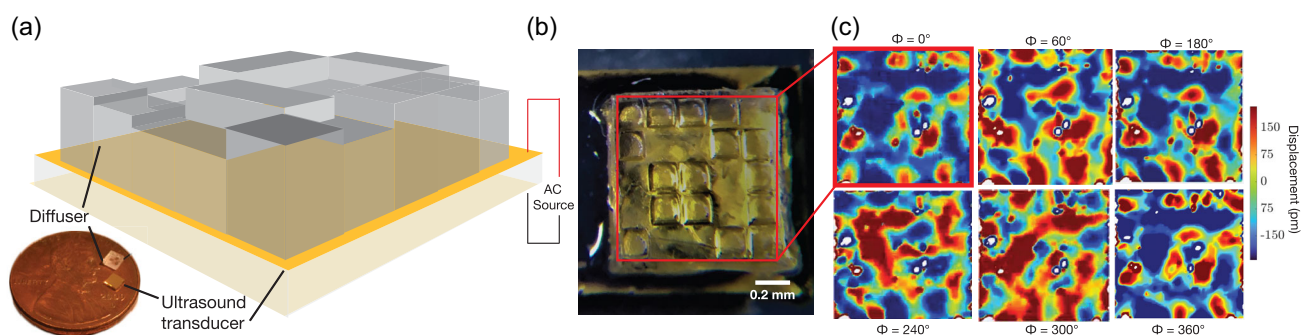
a) A diffuser design based on Schröder's method of quadratic-residue sequences to determine well depth. The wells were machined in glass using a KrF excimer laser system with a custom metal mask to restrict beam width. The machined depth of the pillars is up to 309 μm . b) The glass diffuser block was then c) bonded to a transducer operating in the thickness mode at 7 MHz using an ultraviolet light-curable epoxy. (c) A scanning laser Doppler vibrometer image of the diffuser face in the time domain shows phase differences corresponding to pillar heights (normalized autocorrelation > 0.73).
